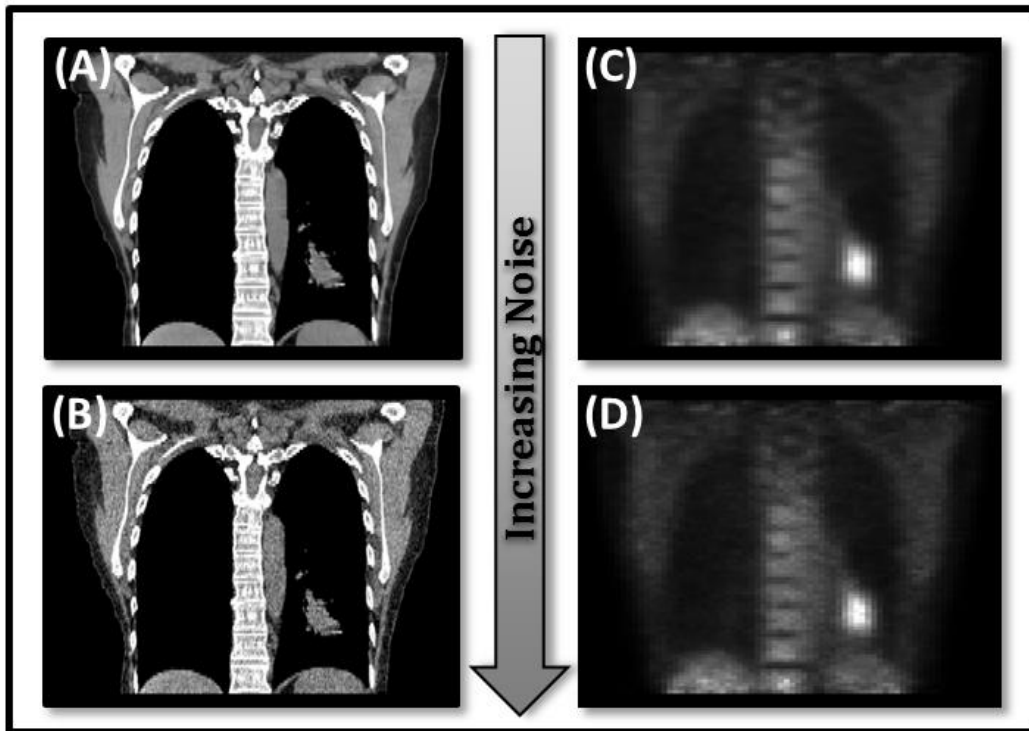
One coronal slice of a PET/CT image with and without noise. (A) Original image. (B) CT image with Gaussian noise ( $\sigma = 120$  HU). (C) PET image without noise. (D) PET image with Gaussian noise ( $\sigma = 0.06 \times \text{maximum intensity}$ ).
